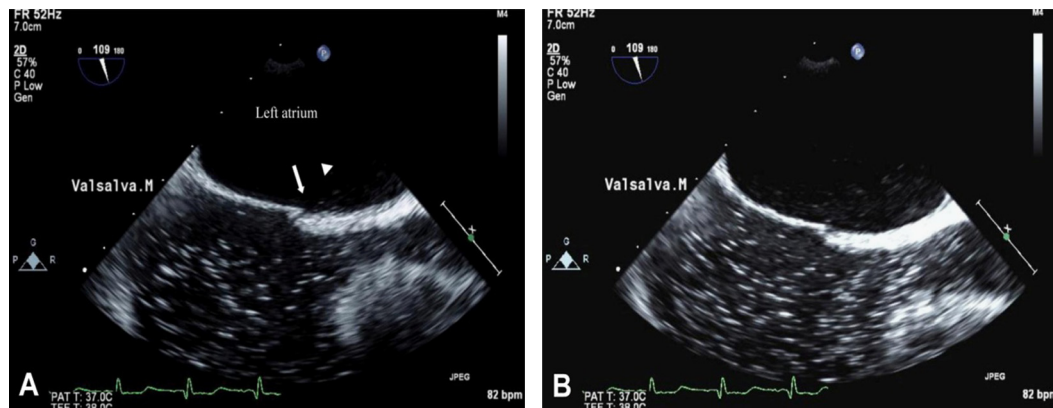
Bubble contrast transesophageal echocardiography. Agitated saline was injected via a peripheral vein and the bubbles reached the right atrium. (A) Opacification of the right atrium was seen initially and the bubbles (arrowhead) passed into the left atrium through the small opening in the PFO (arrow) during the Valsalva maneuver. (B) Many bubbles were seen in the left atrium at the end of a sustained Valsalva maneuver.
